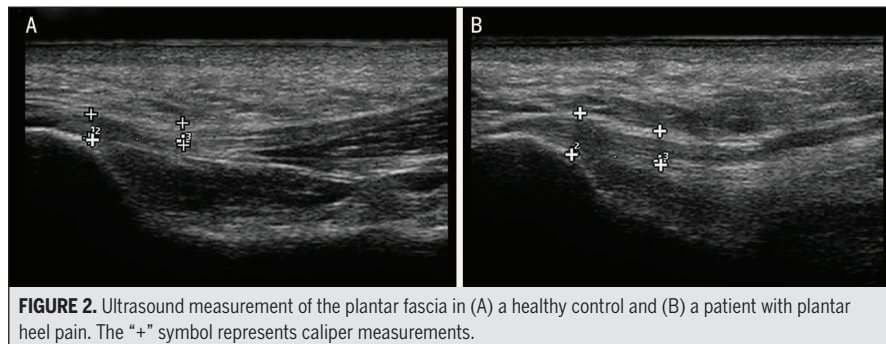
Ultrasound measurement of the plantar fascia in (A) a healthy control and (B) a patient with plantar heel pain. The "+" symbol represents caliper measurements.
